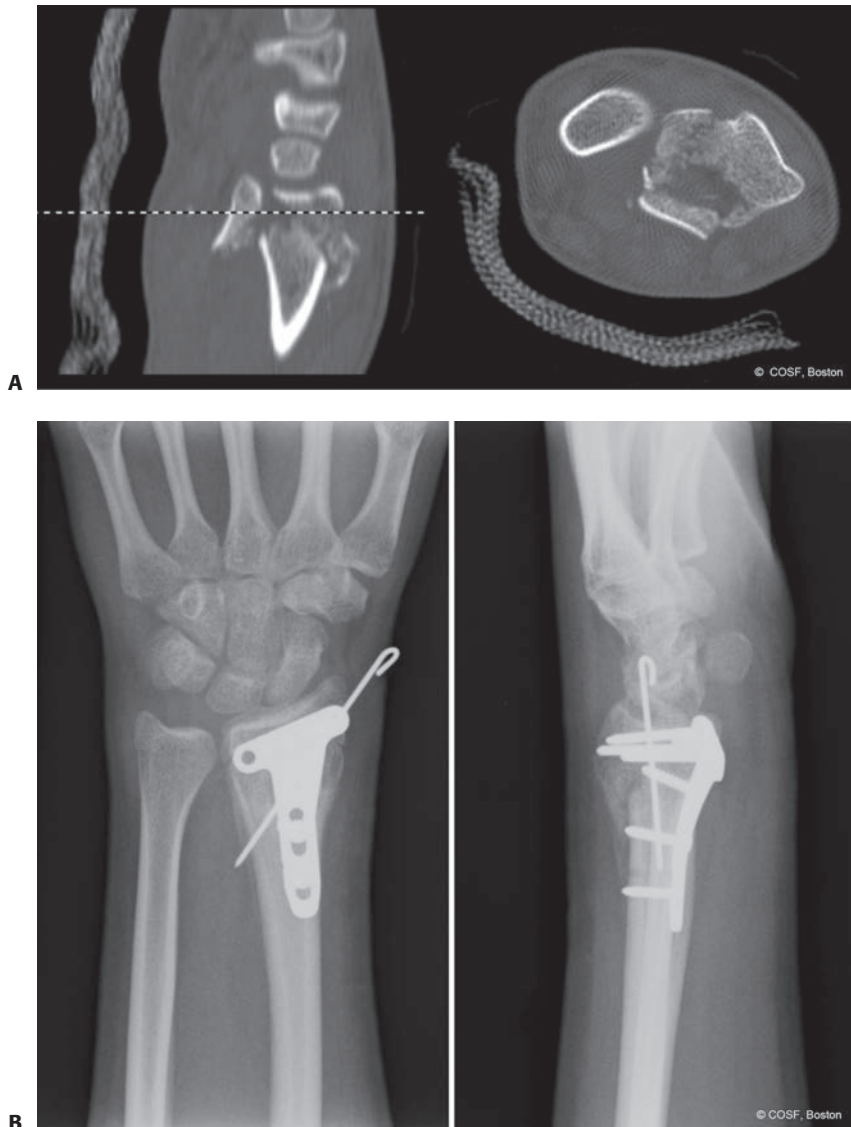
ORIF of distal radius with T plate and supplemental pin fixation. A: Injury CT scan revealing intra-articular displacement. B: ORIF with T buttress plate and supplemental styloid pin 1-month postoperative.
